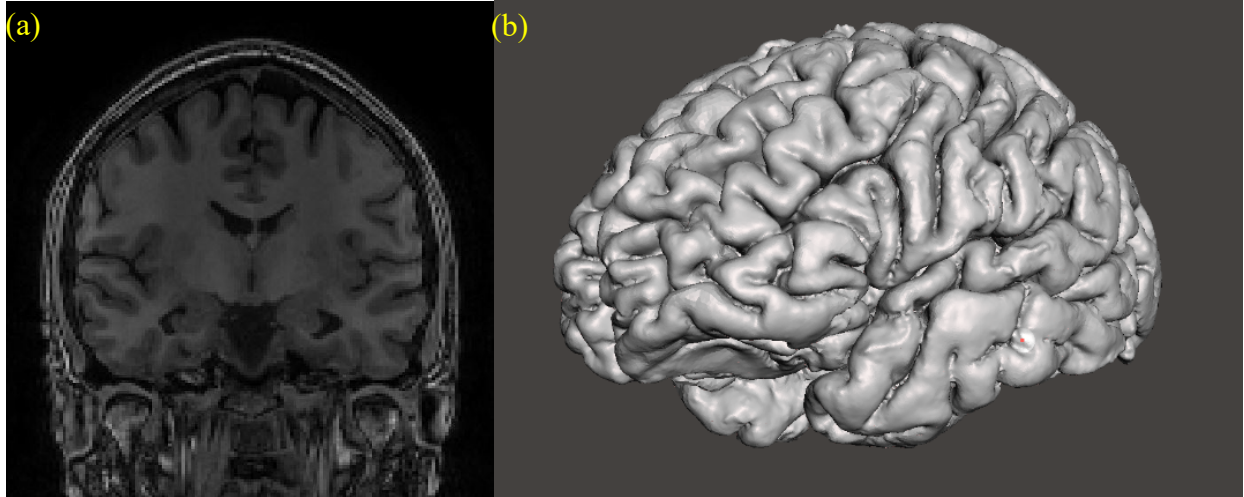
Brain model after the completion of segmentation and reconstruction of MRI. a) MRI images before
